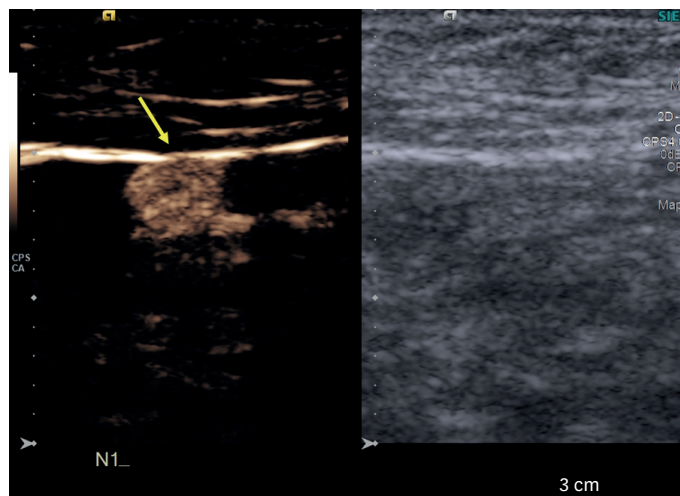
Example of a study case. The patient is a 53-year-old female diagnosed with an invasive lobular carcinoma located in the right breast at the 12 o'clock position, measuring 1.2 cm. Dual-image contrast-enhanced ultrasound and B-mode of the sentinel lymph node (arrow).
